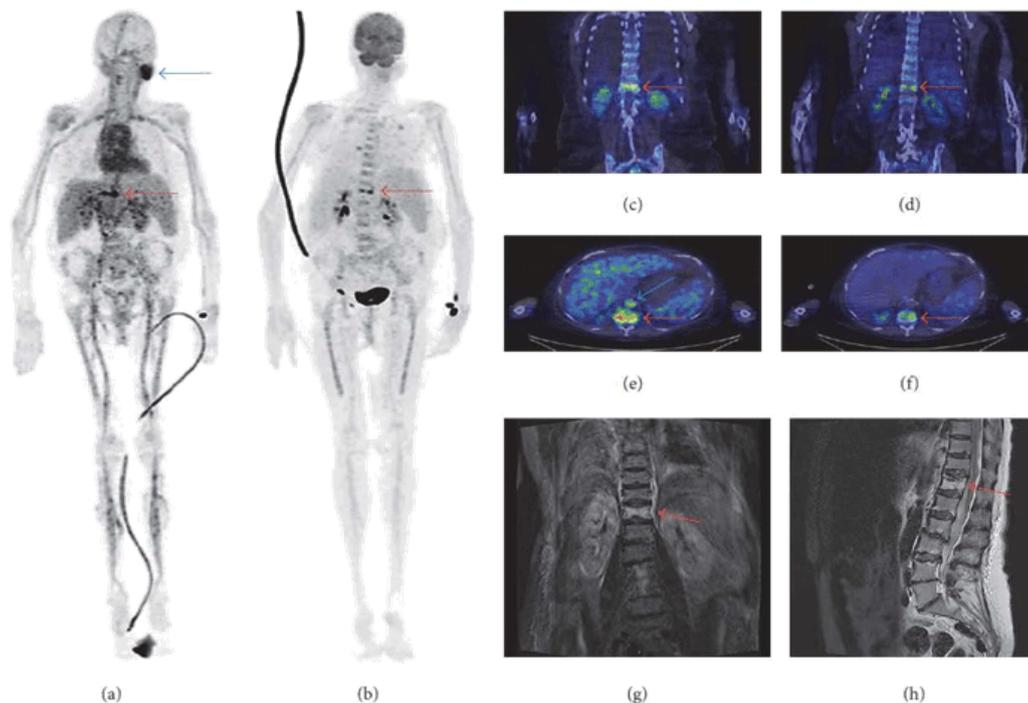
Patient was a 70-year-old woman (weight: 69 kg), with multiple background diseases, who was admitted to hospital because of back pain and high fever. Both ^{68}Ga -citrate (a, c, e) and ^{18}F -FDG PET/CT (b, d, f) showed vertebral osteomyelitis (spondylodiscitis) in Th12 (red arrows) and pneumonia in both lungs. MRI showed oedema in Th12 (g, h). ^{68}Ga -citrate PET/CT also revealed uptake in the left parotid gland (unspecific; (a), blue arrow), neck lymph nodes (reactive), and inferior vena cava (thrombosis; (e), blue arrow). There was no ^{18}F -FDG uptake in these areas. The injected radioactivity dose of ^{18}F -FDG was 279 MBq and the PET acquisition started 50 min after injection. The injected radioactivity dose of ^{68}Ga -citrate was 199 MBq and the PET acquisition started 100 min after injection. MRI sequences were as follows: T2-weighted short inversion time inversion recovery (STIR) on the coronal view image (left) and T2-weighted on the sagittal view image (right). Reprinted with permission from Contrast Media & Molecular Imaging, originally published by Salomaki et al.[51]
